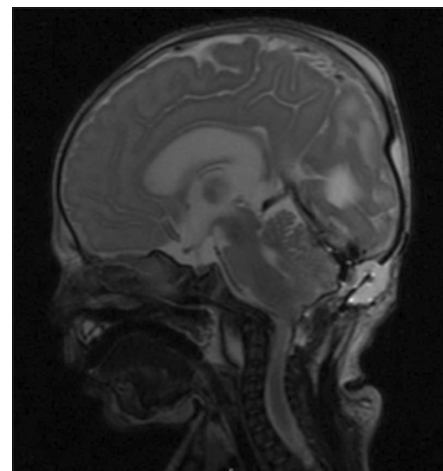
Postoperative sagittal T2-weighted image showing gross total resection with decompression of the cerebellum
